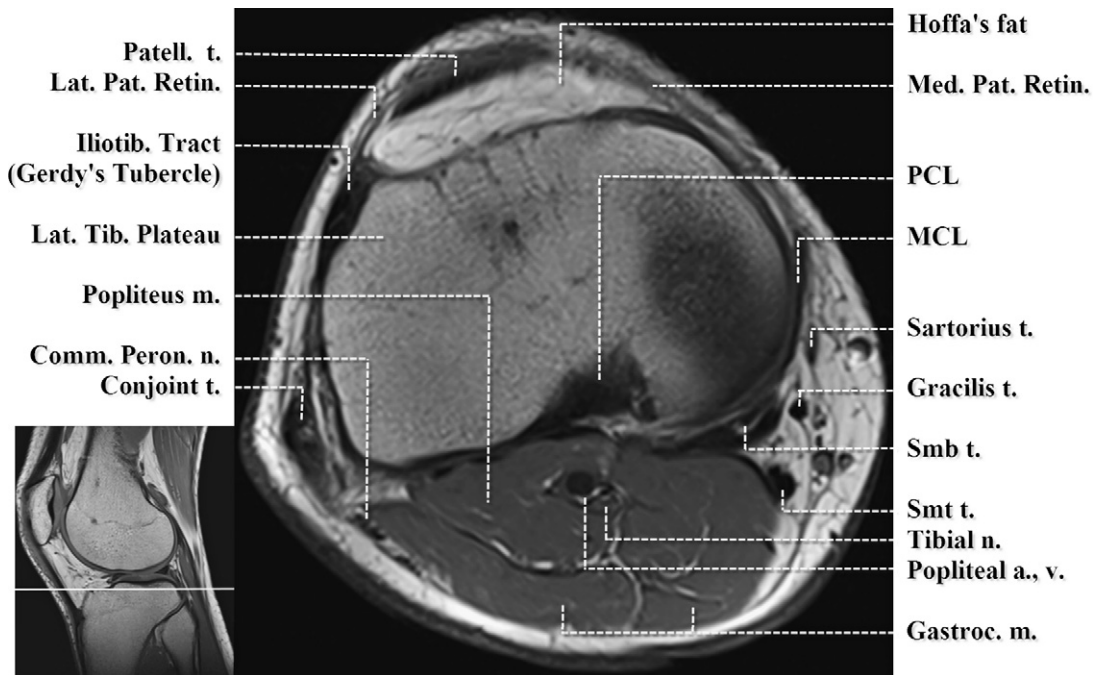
Axial T1-weighted image. Proximal tibia immediately below femorotibial joint line. a., artery; Comm. Peron. n., common peroneal nerve; Gastroc., gastrocnemius; Iliotib., iliotibial; Lat. Tib., lateral tibia; m., muscle; MCL, medial collateral ligament; Med./Lat. Pat. Retin., medial and lateral patellar retinacula; n, nerve; Patell., patellar; PCL, posterior cruciate ligament; Smb, semimembranosus; Smt, semitendinosus; t., tendon; v., vein.
